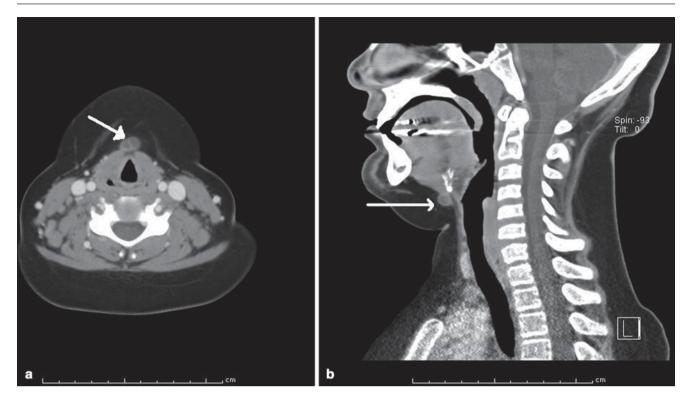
a, b CT scan with arrows indicating the location of a thyroglossal duct cyst
